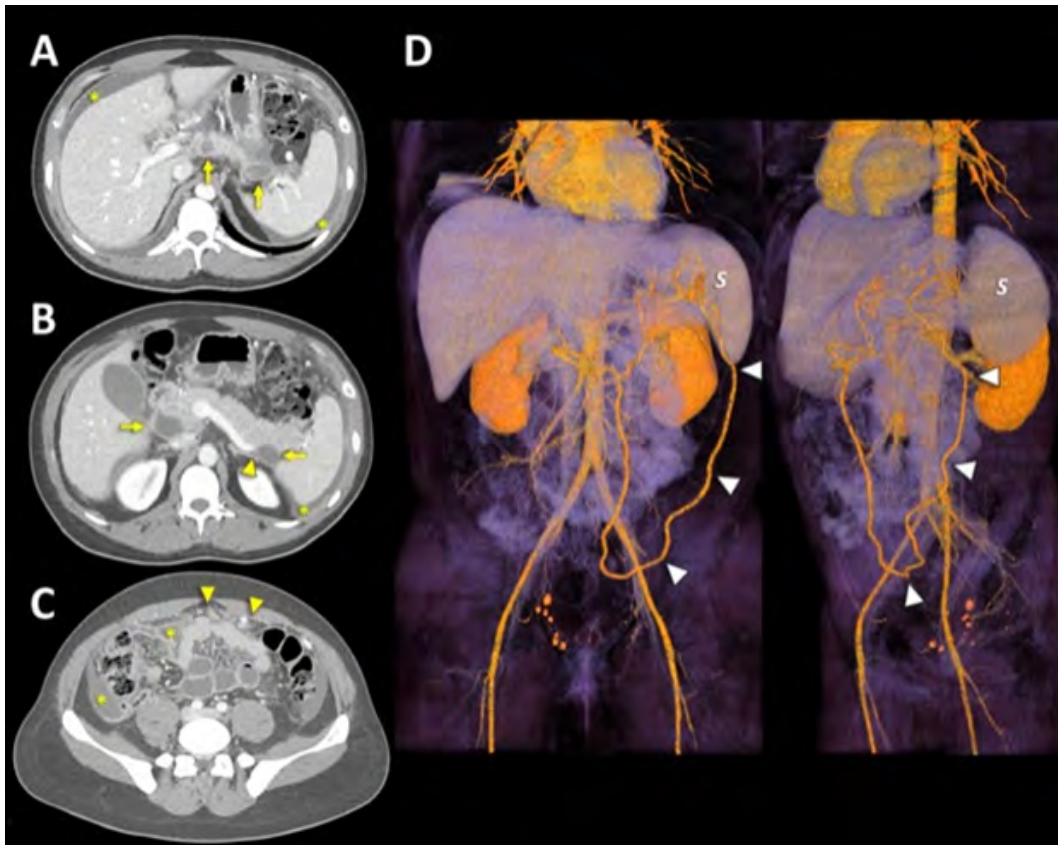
Axial CT images in the venous phase (A–C, from cranial to caudal) showing the enlargement of the pancreas presenting with multiple hypoattenuating lesions with peripheral rim enhancement and thickening (arrows in A and B). Note the abrupt cutoff and thrombosis of the distal splenic vein encased by the hypodense mass at the posterior margin of the pancreatic tail (arrowhead in B), the mild abdominal ascites with peritoneal thickening and enhancement (asterisks in A–C), and micronodular omental thickening (arrowheads in C). 3D image reconstructions (D) showing a compensatory mesenteric collateral vessel via a large omental vein in the left abdomen in communication with the splenic vein at the splenic hilum (arrowheads). S, spleen.
